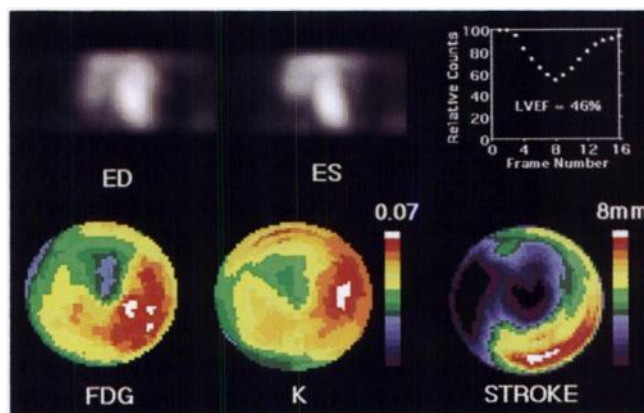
Images from a myocardial viability study are shown for a patient with anterior wall myocardial infarction. The top row shows the volume rendered images at end-diastole and end-systole and the ventricular time-activity curve and ejection fraction. The lower left image is a bull's-eye display of glucose metabolism from the FDG study. The center bull's-eye displays the first-order rate constant of acetate clearance, k_1 , reflecting regional oxygen consumption, here with a maximum value of 0.07/min. The wall motion image of regional contractile function is on the lower right with a maximum wall motion of 8 mm.
